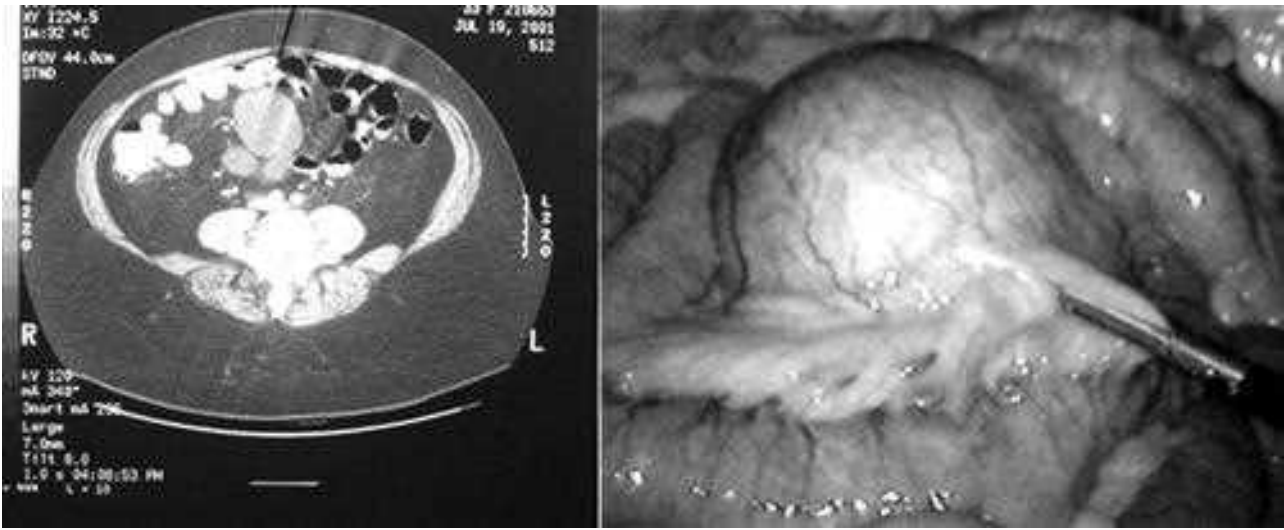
Computed tomography (CT) scan of a mesenteric cyst (*left panel*). Unilocular appearance without associated solid component strongly suggests the diagnosis of benign cyst. The operative findings during laparoscopic exploration (*right panel*) confirm the CT diagnosis of unilocular cyst, which is then enucleated from the mesentery in a relatively avascular plane adjacent to mesenteric vessels.
